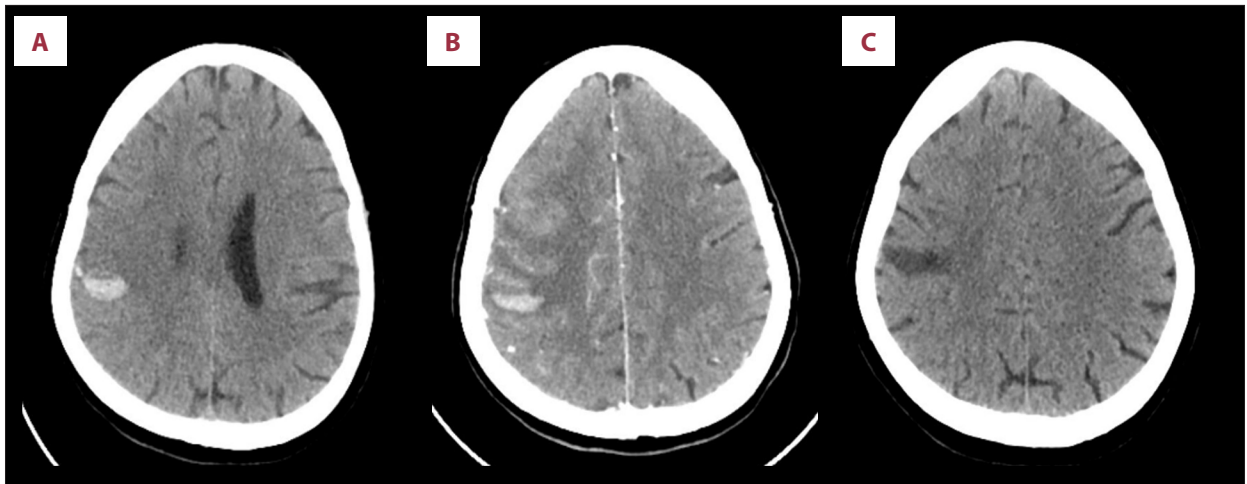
Computed tomography (CT) brain imaging studies performed during hospitalization. (A) Non-contrast-enhanced CT of the brain performed on day 6 following the onset of a generalized tonic-clonic seizure reveals a newly developed intra-axial acute hematoma in the right high frontoparietal subcortical region. Adjacent hyperdense cortical veins are noted, suggestive of thrombosed cortical veins. (B) Follow-up CT angiography of the brain and neck on day 11 demonstrates unchanged right-sided peripherally located hyperdense/thrombosed superficial superior cerebral veins draining to the superior sagittal sinus. Otherwise; no filling defect in dural venous sinuses. Plain CT images show stable multiple foci of intra-axial acute hematoma noted at the right frontoparietal lobe. (C) Follow-up non-contrast-enhanced CT of the brain performed 2 weeks after discharge (day 23) shows interval resolution of the previously noted right frontoparietal intraparenchymal hyperdense hematoma, now appearing hypodense, with resolution of the associated vasogenic edema.
